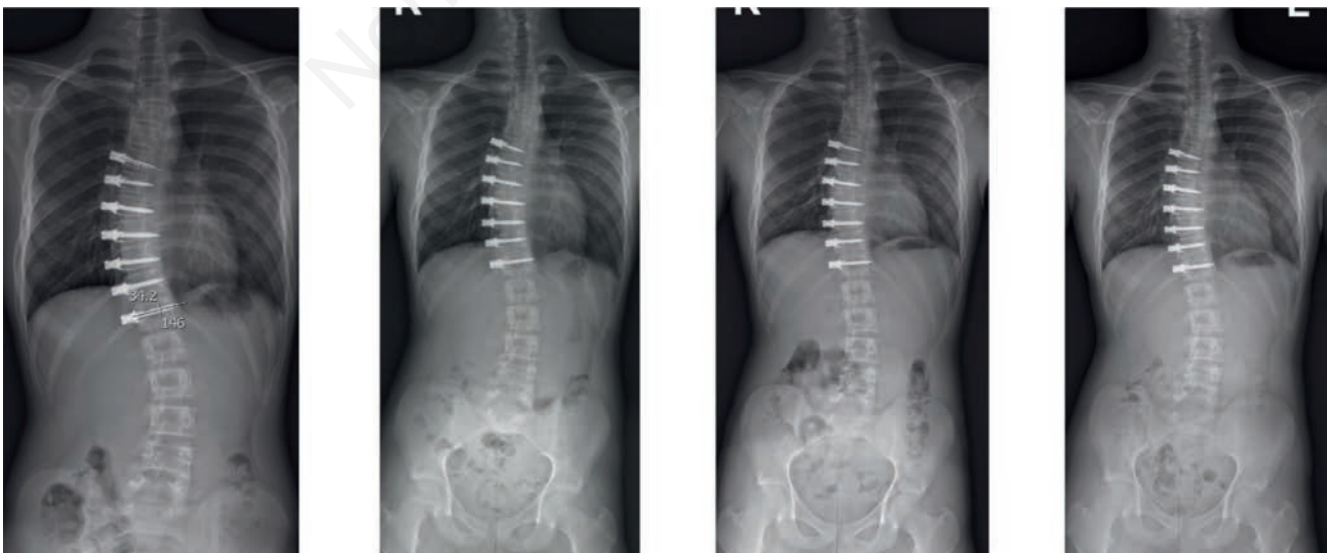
Post-operative X-rays of the same patient in figure 1 showing Cobb angle 24° on postoperative X-rays, 21° six months after surgery, 20° 1 year after surgery and 17° 2 years after surgery.
